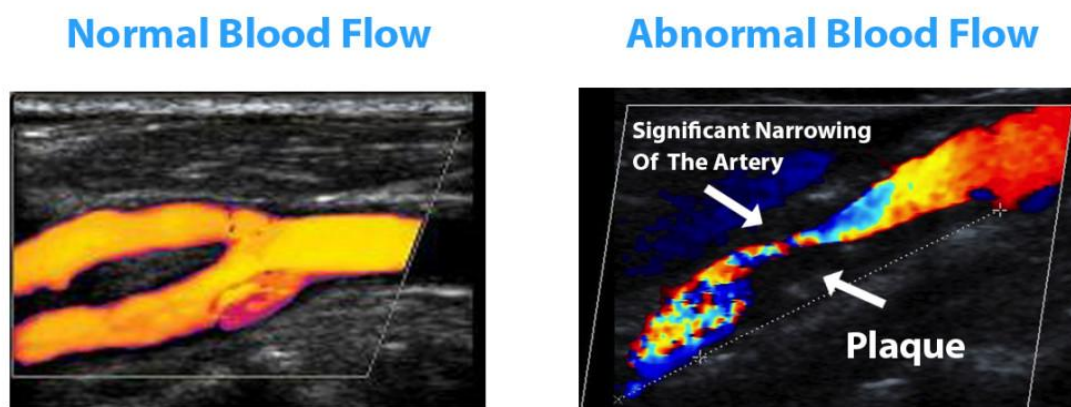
Carotid Doppler ultrasound: Normal Blood flow (left); Abnormal Blood Flow¹⁵¹
